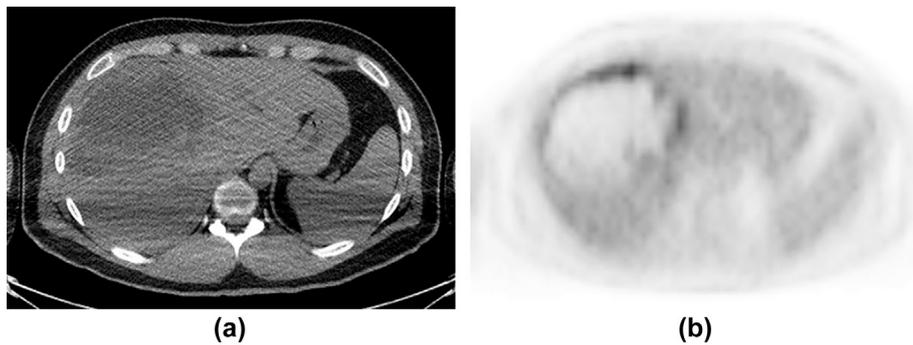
Unfused (a) unenhanced CT and (b) FDG-PET imaging from a combined PET/CT study demonstrate patchy peripheral uptake with absent uptake within the central cystic component.
